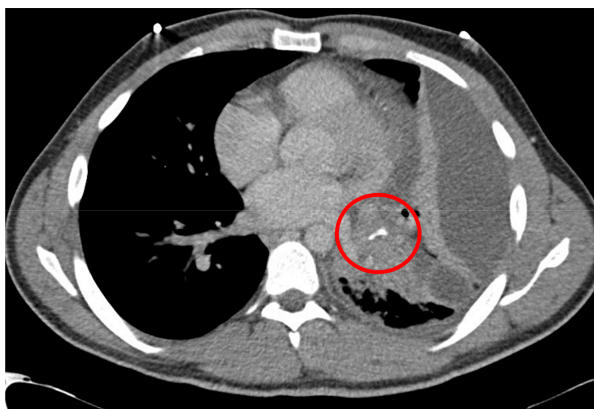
Initial computed tomography thorax which showed a curvilinear calcification in the mass.
